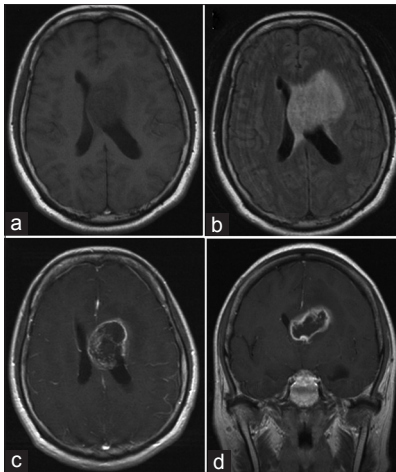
The preoperative MRI of the brain. Preoperative MRI of the brain. (a) Unenhanced T1-weighted MRI, axial section. (b) T2-weighted MRI, axial section. (c) Gadolinium-enhanced T1-weighted MRI, axial section. (d) Gadolinium-enhanced T1-weighted MRI, coronal section. MRI – Magnetic resonance imaging
